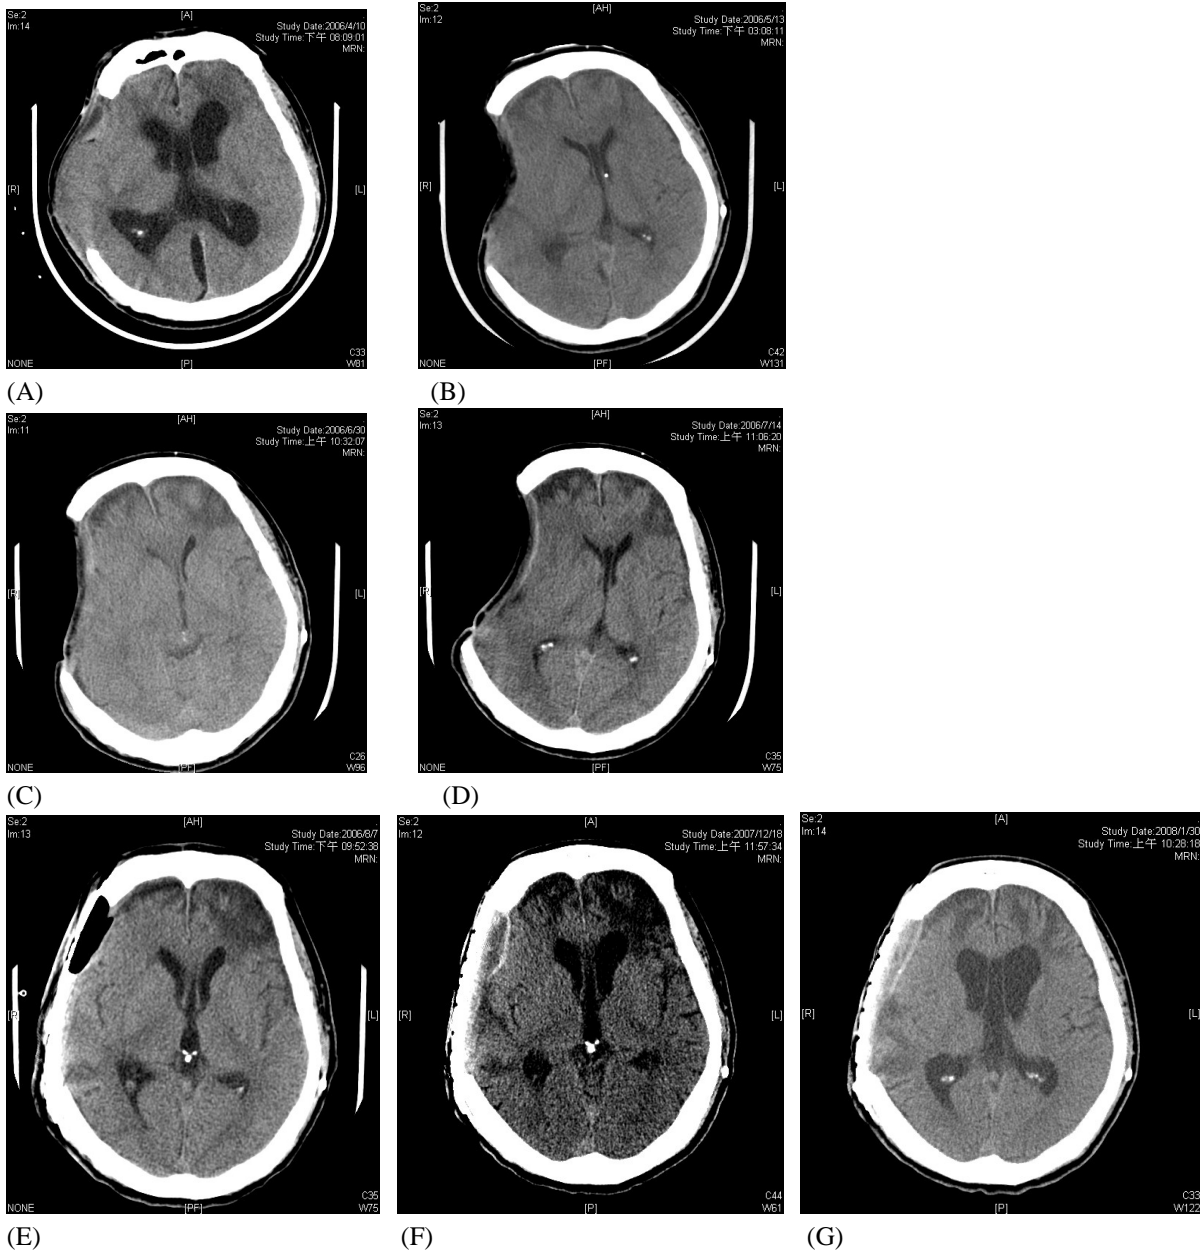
(A) CT image of the patient 1 month after the patient sustained a severe TBI with hydrocephalus and periventricular lucency; (B) CT image of the patient after the VP shunt was performed; (C) Slitlike configuration of the lateral ventricles under VP shunt with medium-pressure setting valve; (D) mild degree of slitlike ventricle under VP shunt with high-pressure valve; (E) CT image of the patient after cranioplasty with high-pressure setting valve and ASD insertion; (F) CT scans after programmable VP shunt system performed with pressure setting at 140 mmH₂O; (G) CT scans with programmable VP shunt system with pressure setting at 70 mmH₂O.
